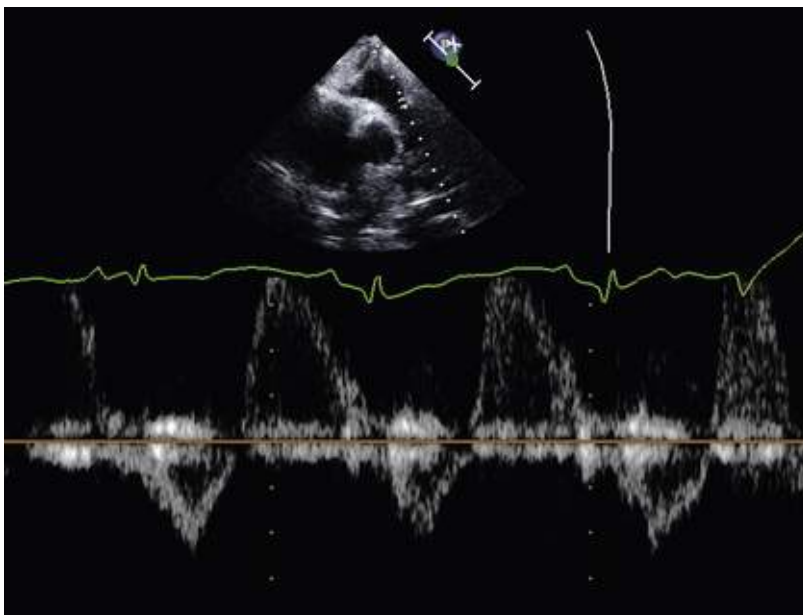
PW Doppler interrogation of the RVOT in a patient who has undergone pulmonary valvotomy. There is severe pulmonic regurgitation resulting in a laminar regurgitant signal.
